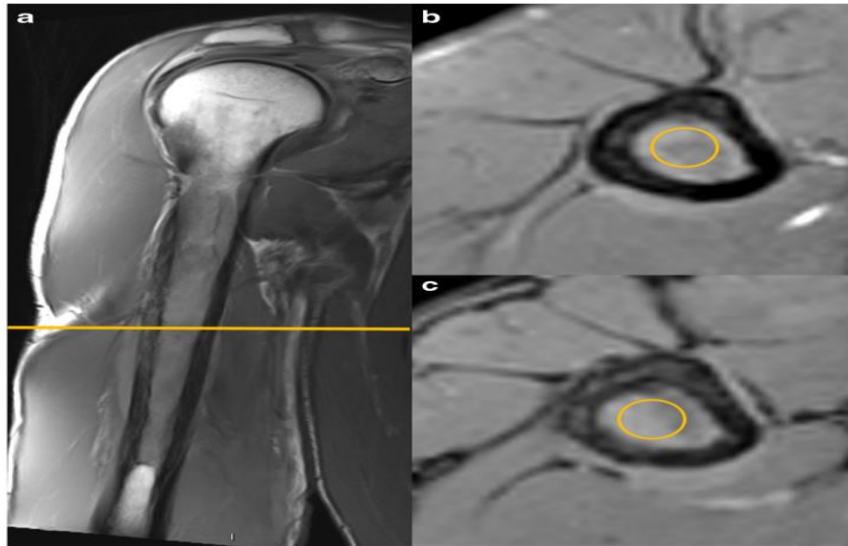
A 41-year-old man with lymphoma of the right humerus. Coronal T1-weighted image shows a marrow-replacing process in the diaphysis. Signal drop out on CSI is calculated using the qualitative method to measure the signal loss percentage (Q-ROI method). An ROI is drawn in a location of the least signal drop on the axial OP (Fig. 1c) compared with IP (Fig. 1b) based on qualitative/visual assessment. Then calculated using this formula: $[(SI (IP)-SI (OP)) / (SI (IP))] \times 100$. The signal drop % was 4% compatible with marrow replacement ⁽⁶⁾.
